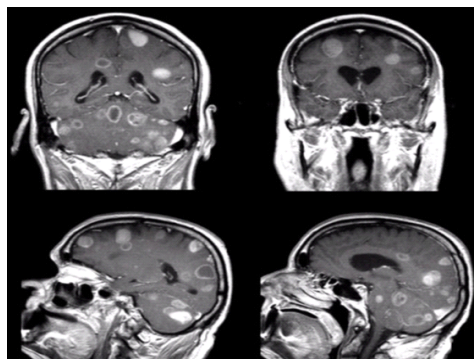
MRI brain gadolinium enhanced T1W images showing cerebral metastases in a patient with carcinoma lung.
